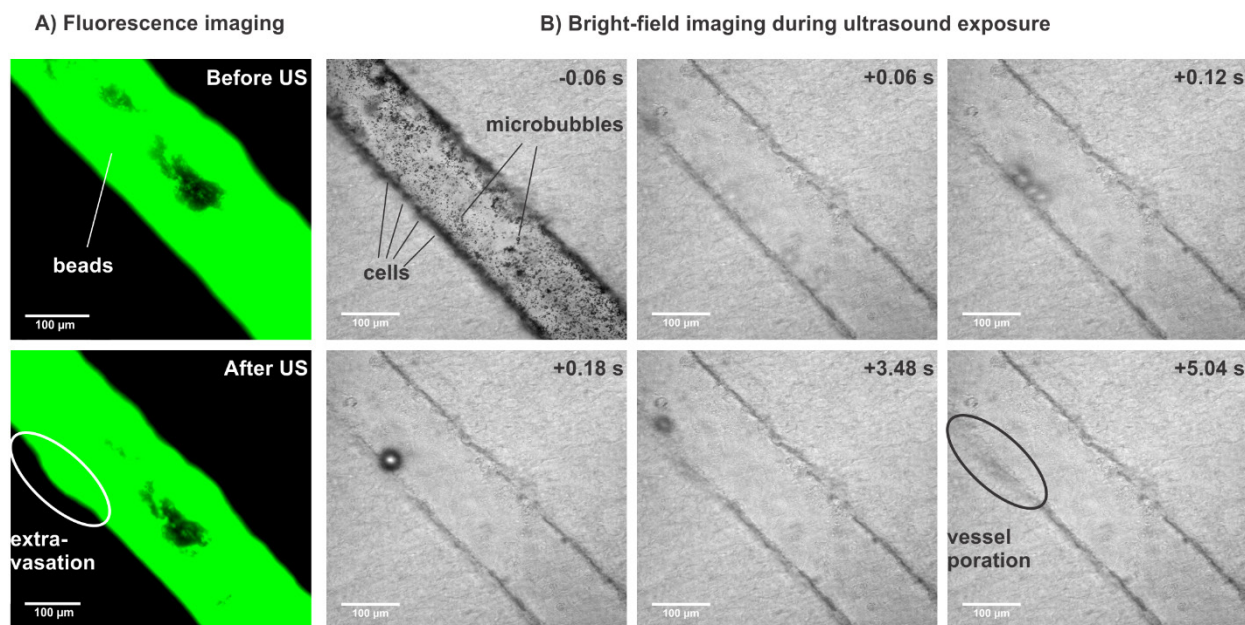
A) Fluorescent images acquired before and after ultrasound exposure. B) Still frames of a bright-field recording acquired during ultrasound exposure (starting at $t=0$ s and ending at $t=5$ s). Upon ultrasound exposure, microbubbles oscillate, cluster and coalesce into a large microbubble (frame +0.18s), leading to the disruption of the endothelial vessel wall (frame +5.04s). The fluorescent image acquired after ultrasound exposure indicates that beads have extravasated from the microvessel into the collagen matrix.
